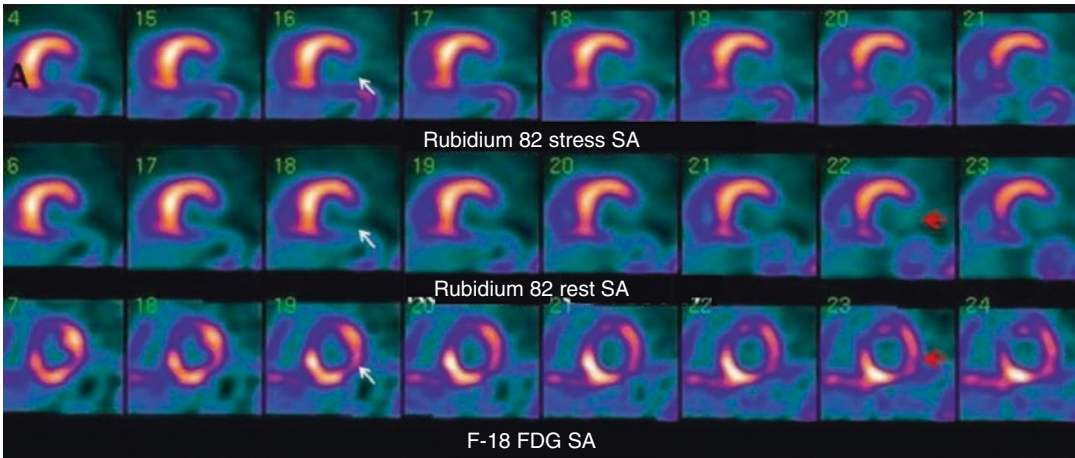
Selected short axis frames of Rubidium-82 and F-18 FDG are shown. Viable myocardium is indicated by filling of the inferior-lateral defect by activity on FDG
